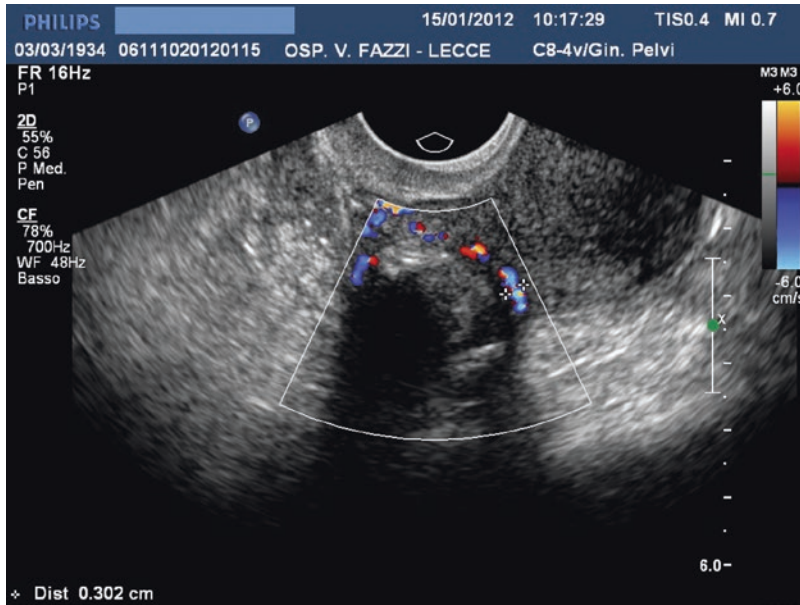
Ultrasonographic image of posterior subserosal fibroid, preoperatively scanned by echo color Doppler, highlighting the “ring of fire”
